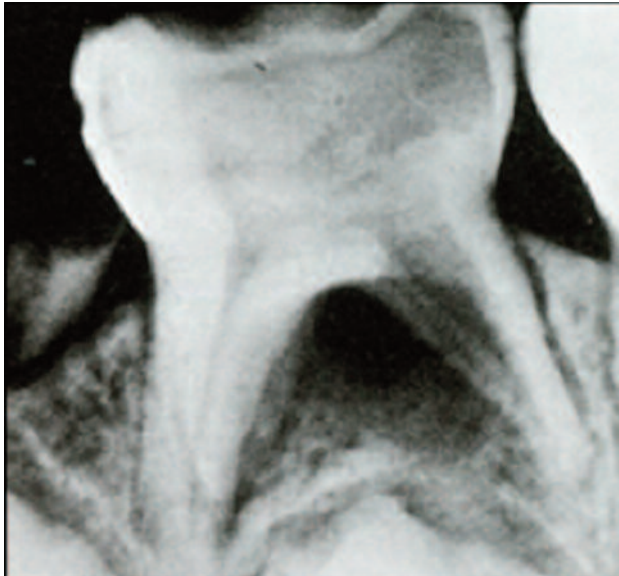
Radiographic image of a temporary inferior molar with an interradicular lesion<sup>8</sup>
